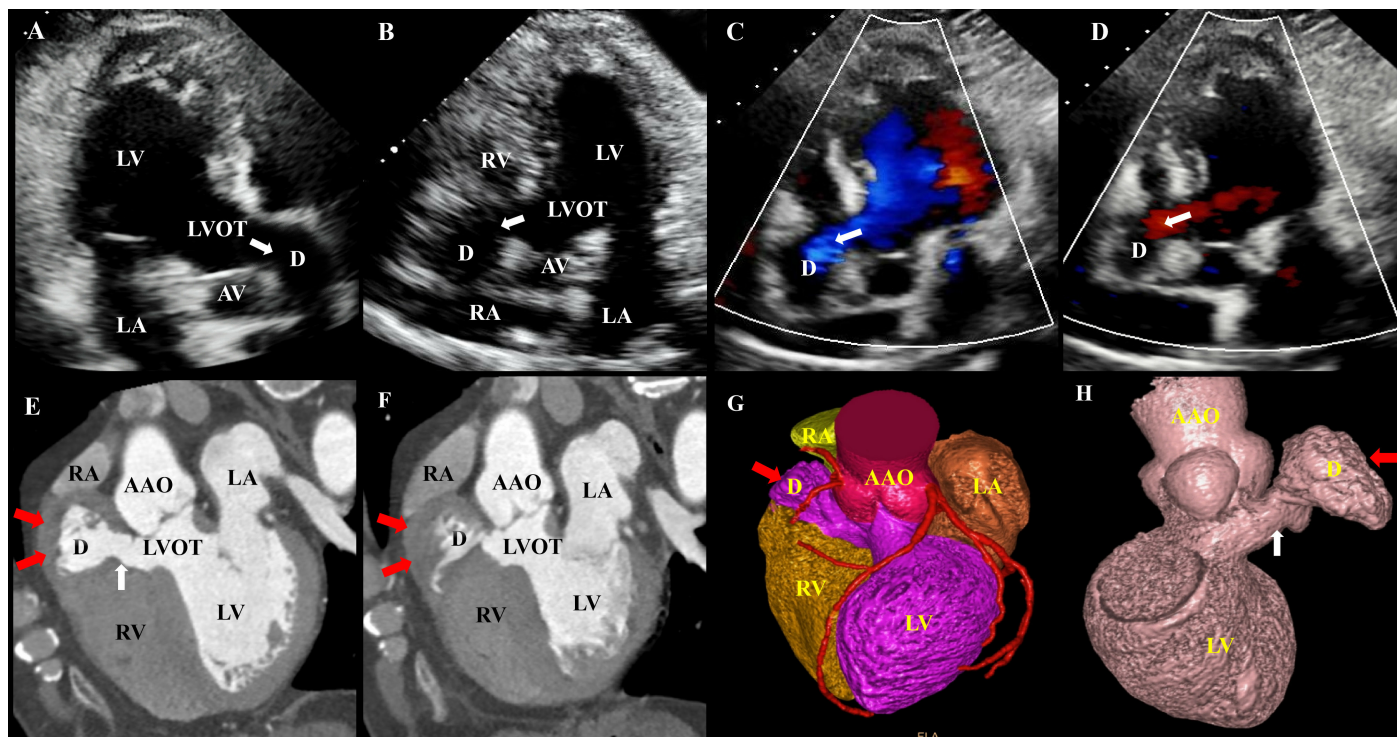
(A-B) Transthoracic echocardiography on apical 3- and 5-chamber views reveal a muscular diverticulum originating from the LVOT and extending toward the right atrioventricular groove. Color Doppler echocardiography reveals blood flowing from the LVOT into the diverticulum during diastole (C) and from the diverticulum into the LVOT during systole (D). (E-F) Cardiac CT angiography reveals the muscular diverticulum (red arrows) is located beneath the right coronary cusp and communicated with the LVOT through a long neck (white arrows). The diverticulum enlarges and its wall thins during diastole, while it decreases in size and its wall thickens during systole. (G) Volume-rendered (VR) imaging clearly showed the anatomical position of the diverticulum relative to the surrounding structures. (H) Volume-rendering (VR) imaging clearly showed the morphology and origination of the diverticulum. AAO, aortic arch; AV, aortic valve; D, diverticulum; LA, left atrium; LV, left ventricle; LVOT, left ventricular outflow tract; RA, right atrium; RV, right ventricle.
